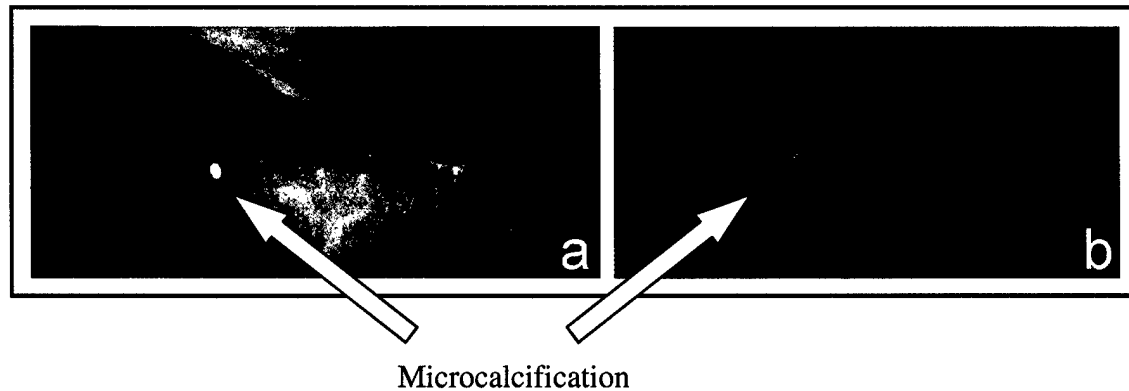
USAE of a breast tissue sample. (a) X-ray image indicating the existence of a microcalcification in the tissue. (b) USAE image obtained at the difference frequency  $\Delta f = 22$  kHz. The microcalcification can be seen in this image.
